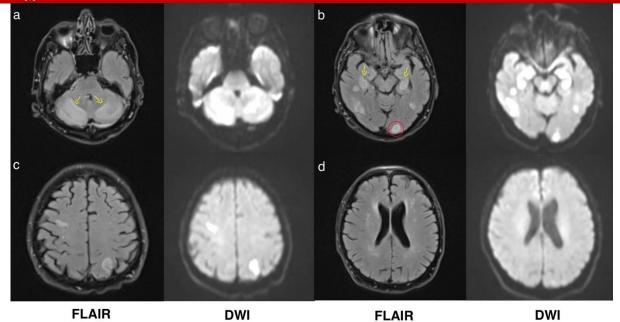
radiographic evidence of multifocal cerebrovascular injury within the MCA and PICA territories, substantiating the diagnosis of an acute ischemic stroke.
